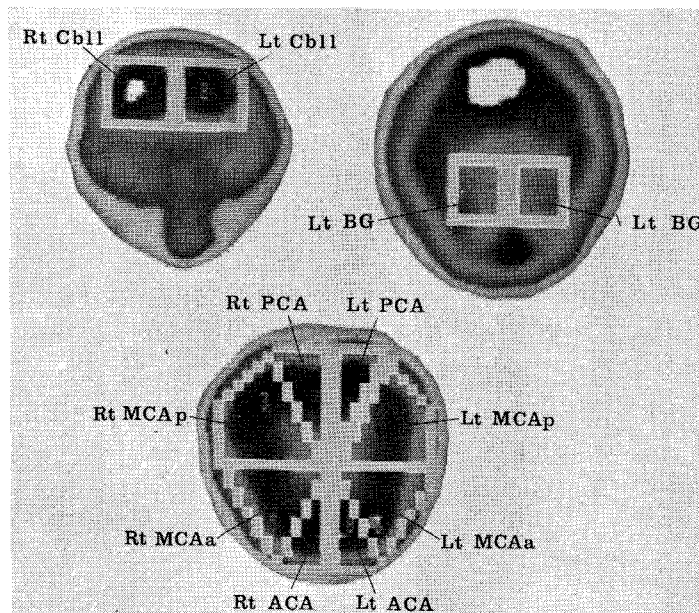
Region of interest as used for quantitative analysis of SPECT images. Rt; right, Lt; left, Cb11; cerebellar hemisphere, BG; area of basal ganglia, PCA; posterior cerebral artery, MCAa; middle cerebral artery (anterior), MCAp; middle cerebral artery (posterior), ACA; anterior cerebral artery.
